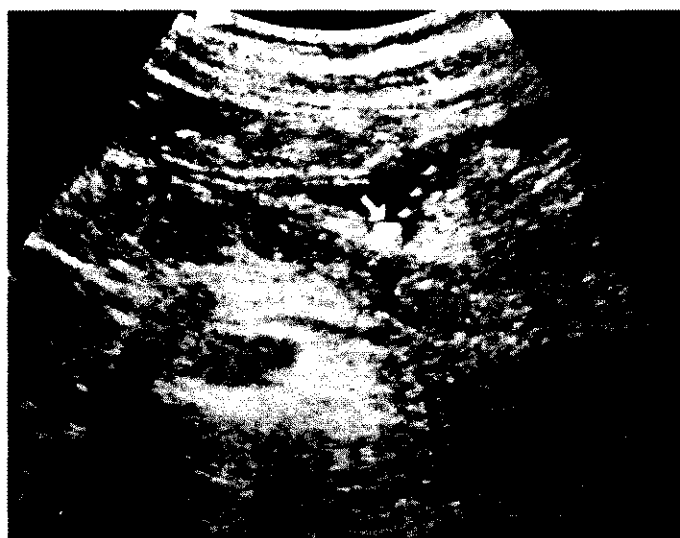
(a) Ultrasound image of the abdomen showing the sagittal section of the left upper quadrant. There is a large pancreatic cyst showing internal echoes consistent with blood, P.D. catheter passed under US guidance having numerous holes seen insitu. Film (b) shows axial image of the left upper abdomen, after resolution of the pseudocyst, with a drain tube insitu (arrow) adjacent to the pancreatic tail.
